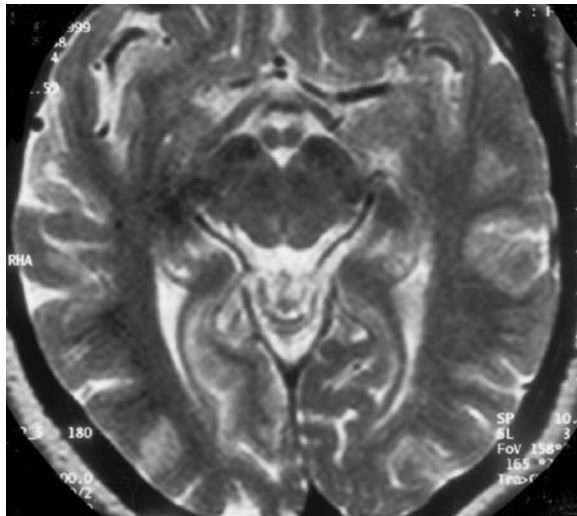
A 57-year-old man with acute homonymous hemianopia to the right. Diagnosis: infarction of the left PCA. MRI: a Axial T2-weighted view with slight hyperintensity in the left subcortical occipital parenchyma and lens-shaped hyperintensity in the left thalamus (*arrow*). The irregularities in the spheroid hyperintensities in the basal ganglia region correspond to pre-existent lacunar defects. b Corresponding T1-weighted native image showing a slight swelling of the occipital lobe and hypointense white matter. c Midsagittal, T1-weighted, contrast-enhanced view showing BBB disruption throughout the entire parenchyma of the occipital lobe. d Contrast-enhanced image (corresponding to b) with demarcation of the entire infarction of the occipital lobe and posterior left thalamus (*arrow*) by signal enhancement due to BBB disruption. (From MÜLLER-FORELL and LIEB 1995)
